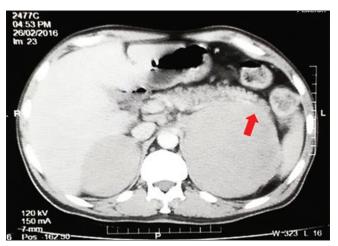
Computed tomography scan image showing bilateral hypoechoic adrenal masses infiltrating the pancreas on the left side (marked by red arrow)
